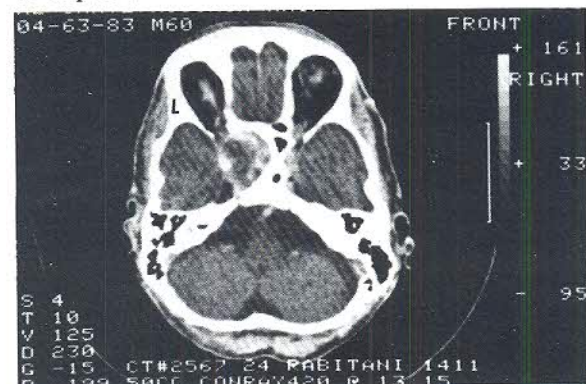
Case 4. CT scan (with IV contrast) shows a mucocoele involving the sphenoid sinus and extending into the left middle fossa.
